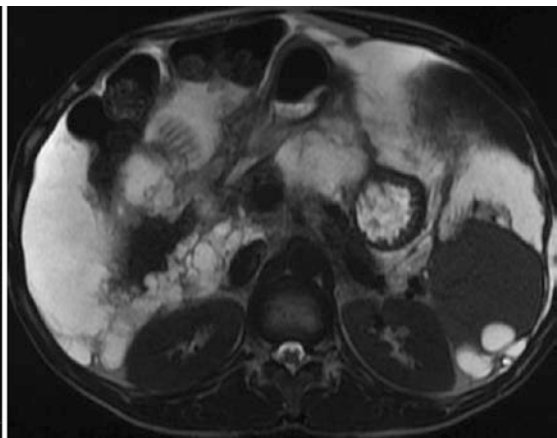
Axial contrast CT showing diffuse organ encasement and spleen scalloping related to pseudomyxoma peritonei or with corresponding image on axial T2-weighted image. Note the T2 hyperintense signal similar to ascites
